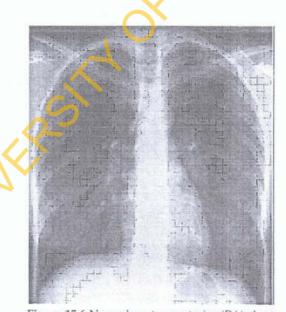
Normal postero-anterior (PA) chest x-ray.
